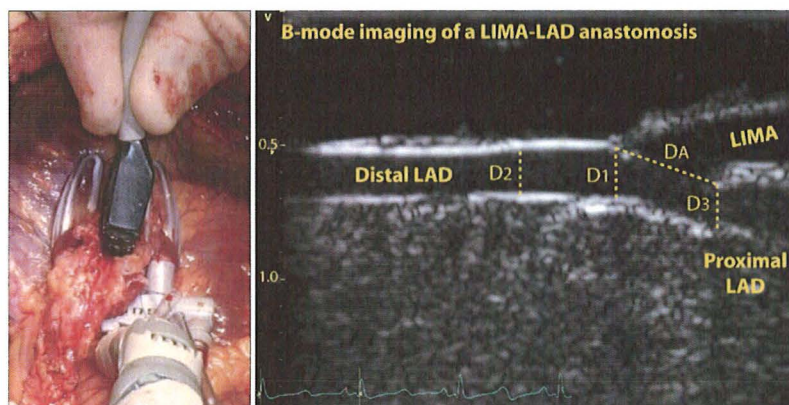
Left: Epicardial ultrasound imaging. A stabilized area around the LIMA-LAD anastomosis is imaged using a Vivid7 ultrasound scanner (GE Vingmed Ultrasound, Horten, Norway) and high-frequency i13L linear array (GE Healthcare, Waukesha, WI). Right: B-mode image of the LIMA to LAD coronary anastomosis as obtained in the study. Diameter measurements indicated were used to determine the quality of the anastomosis. LIMA, Left internal mammary artery; LAD, left anterior descending.
